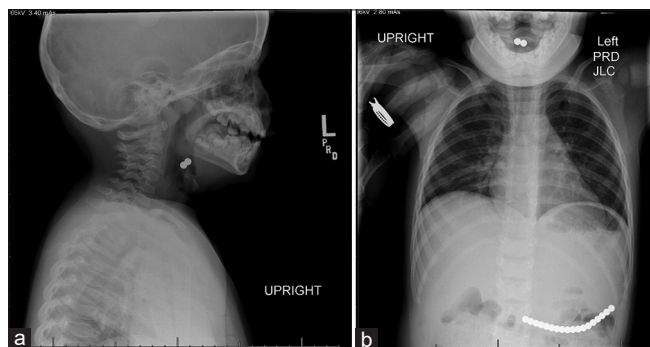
(a) Radiography of the lateral neck (a) and the antero-posterior view of the chest and upper abdomen (b) show two small radio-opaque beads next to the glottic opening and a string of 18 beads in the stomach and proximal duodenum
